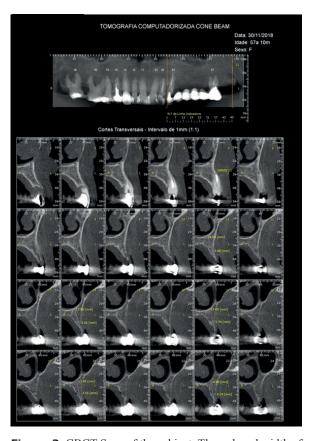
CBCT Scan of the subject. The reduced width of bone ridge is appreciable.
